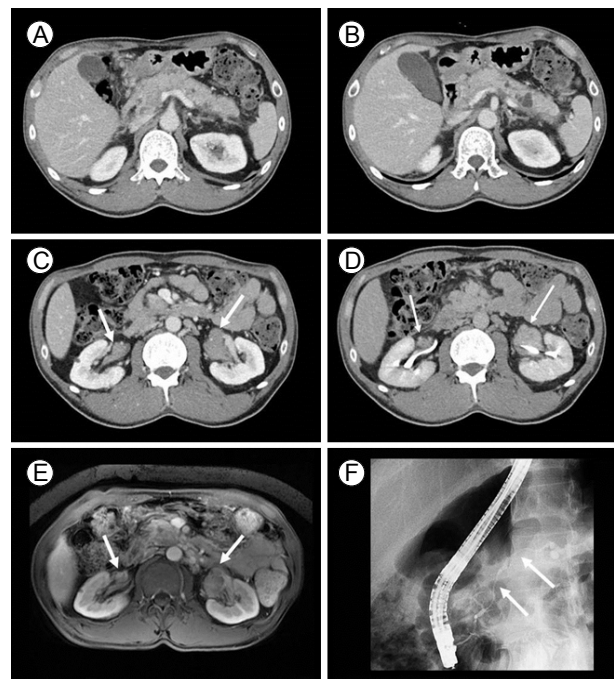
Initial evaluation using contrast-enhanced abdominal computed tomography (CT). (A) CT scan showing diffuse enlargement of the pancreas and peripancreatic fluid collection. (B) CT scan showing multiple cystic lesions without main pancreatic duct dilatation. (C, D) Homogenous masses (arrows) in bilateral renal sinuses and pelvis showing mild enhancement in the nephrographic and excretory phases. Magnetic resonance imaging findings of renal masses. (E) Contrast enhanced T1-weighted image reveals hypovascular renal masses (arrows) showing minimal contrast enhancement. Endoscopic retrograde cholangiopancreatography findings. (F) Pancreatic duct with multifocal irregular strictures (arrows).
